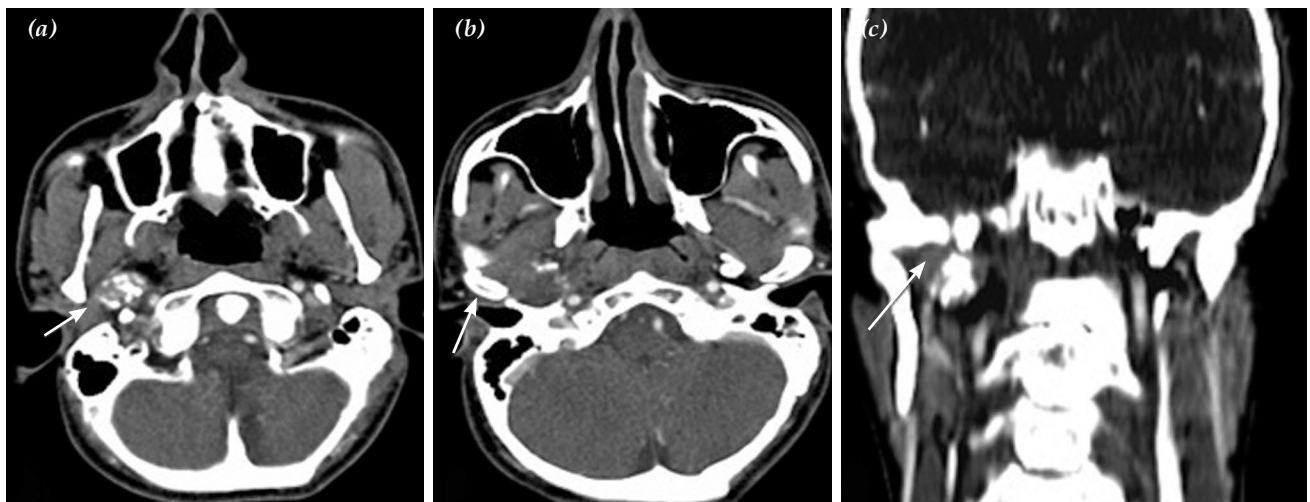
Computed tomography. (a) Axial section after contrast injection shows a mass containing punctate calcifications in the right parapharyngeal space posteriorly, with a well-defined margin and average enhancement with the contrast medium (arrow). (b) The mass is near the right temporomandibular joint (arrow), displacing the mandibular head laterally. (c) Coronal multiplanar reconstruction sections show destruction of the bone of the middle cranial fossa and an indentation in the intracranial area (arrow).
